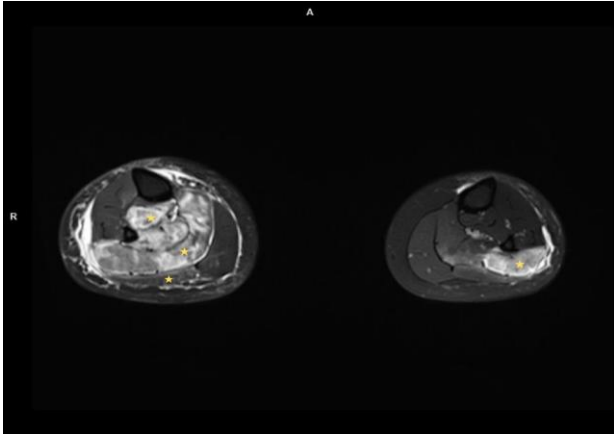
MRI T2-weighted image (Bilateral edema within the right tibialis posterior muscle, right soleus muscle, and the right gastrocnemius muscle, along with edema in the left soleus muscle: yellow stars).
